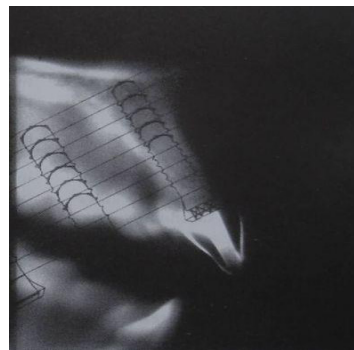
Axial CT view of the mandible showing the potential crosssectional slices that can be reformatted by Dentascanner
